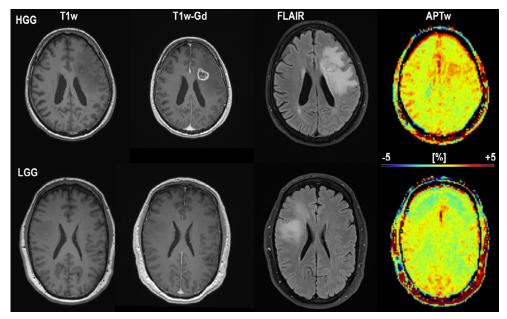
Difference in APTw% signal in HGG vs. LGG Conventional MRI; T1-MPRAGE without contrast, T1-MPRAGE with Gadolinium, FLAIR and APTw in color for one subject exhibiting a high grade glioma and one patient with a low grade glioma. Of note is the increased APTw% signal in the HGG vs. the LGG, shown on APTw color maps.
